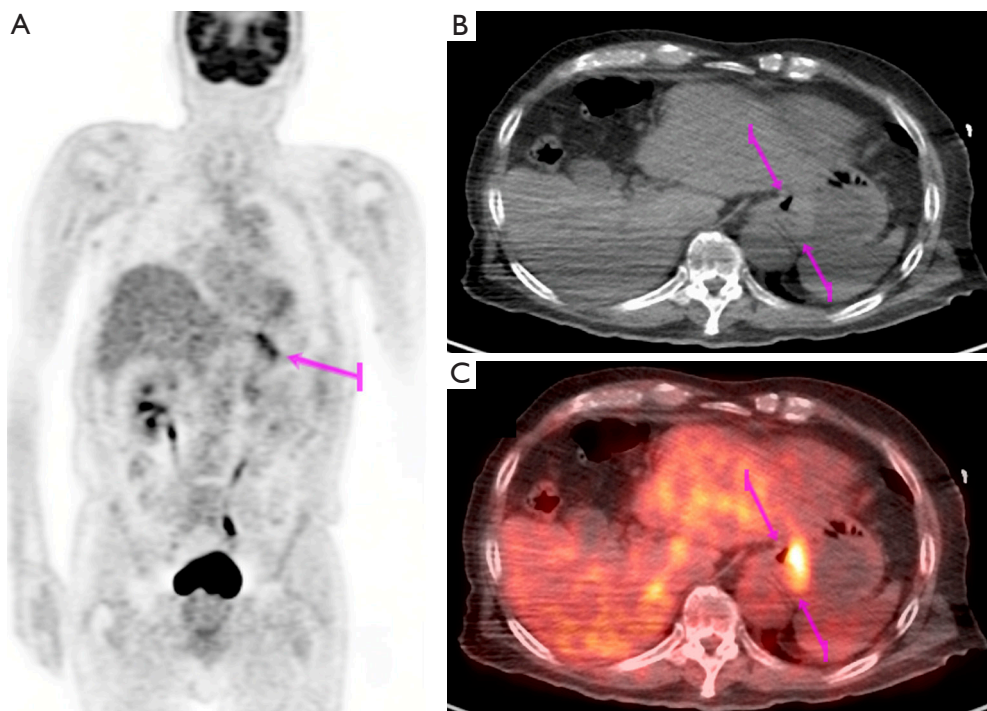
PET/CT imaging of gastric malignancy prior to neoadjuvant therapy. Coronal PET (A), Axial CT (B) and Axial Fused PET/CT (C) images circumferential wall thickening involving the gastric cardia with associated hypermetabolism (arrows) compatible with a primary gastric malignancy.
